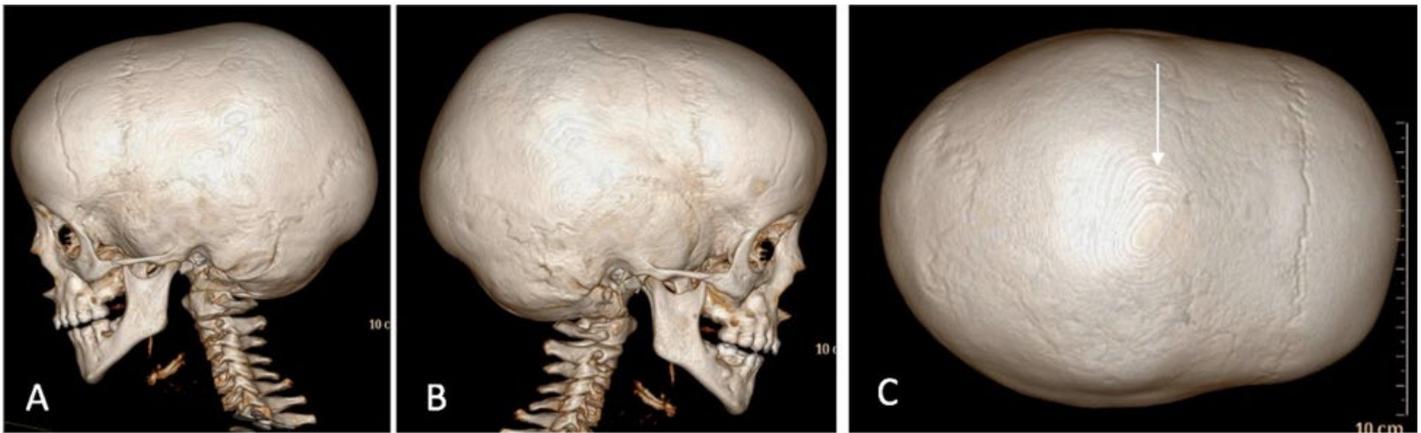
CT scan with 3D reconstruction showing: A–B) lateral view; C: vertex view.
